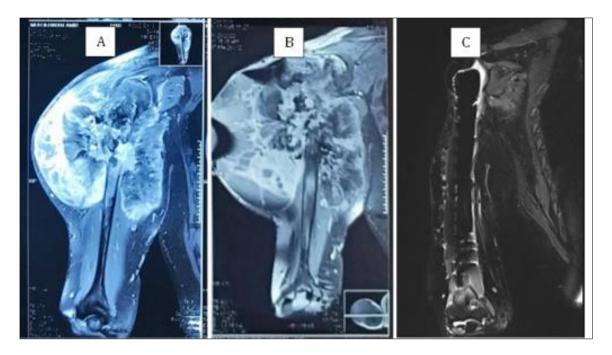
Right Humerus MRI (A) Pre-neoadjuvant chemotherapy (B) Post neoadjuvant chemotherapy (C) 4 months post-operative
